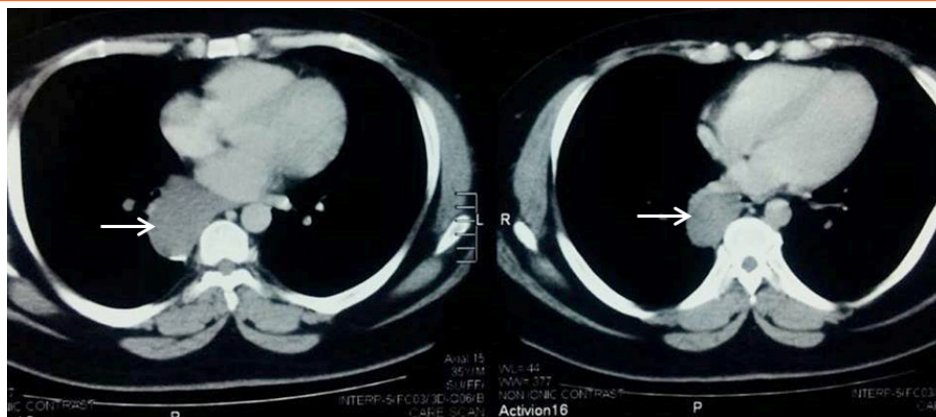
Axial view of chest CT showing paravertebral bronchogenic cyst in the posterior mediastinum with well-defined margins and homogenous content (arrows).
